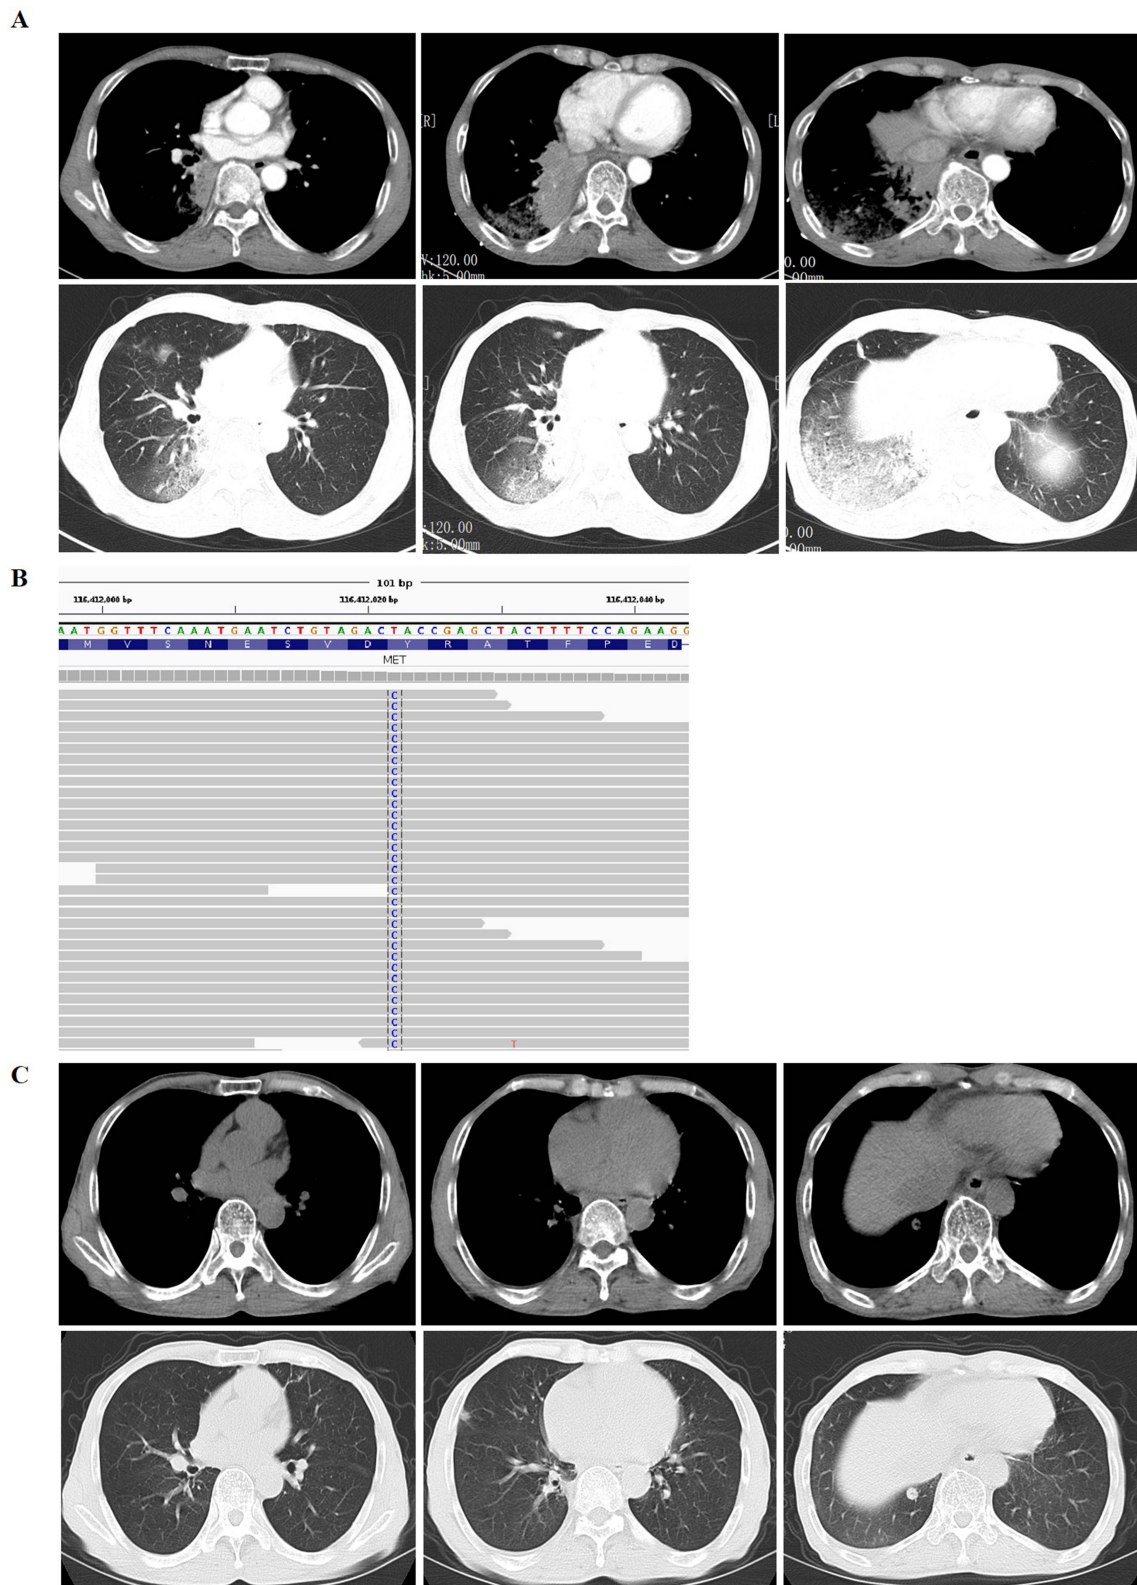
The patient's initial diagnosis and lesion changes after treatment. (A) CT result of initial diagnosis. (B) *MET* Y1003H mutation was found. (C) Lesions assessment after treatment.
